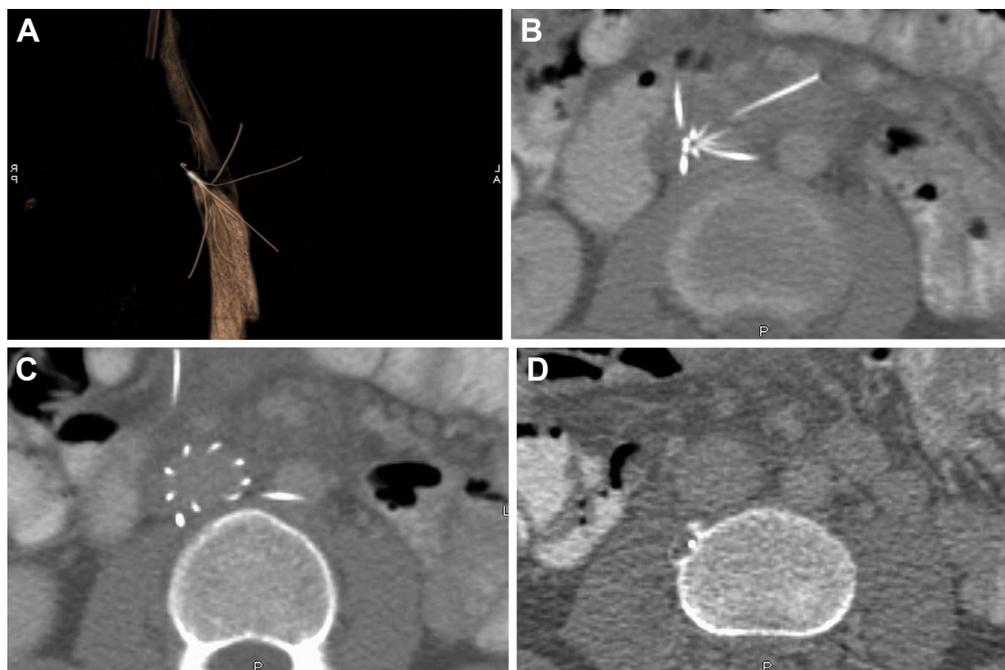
Three-dimensional reformatted image of the inferior vena cava (IVC) demonstrates most of the filter limbs extending beyond the walls of the IVC (A). Axial computed tomography (CT) shows perforation of the IVC filter limbs through the wall and extending into the duodenum (B), abdominal aorta (C), and lumbar vertebral body (D).
